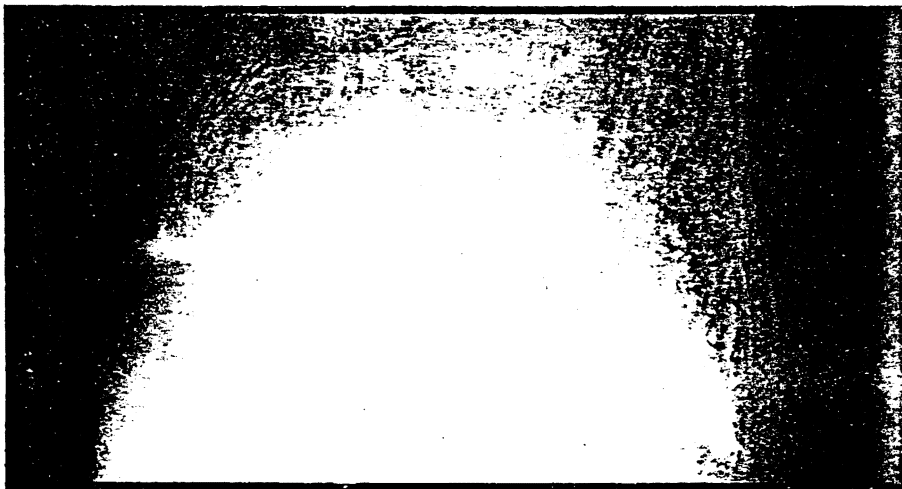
The roentgenographic appearance of the left talus with the adjacent bones in patient C demonstrating avascular necrosis.
